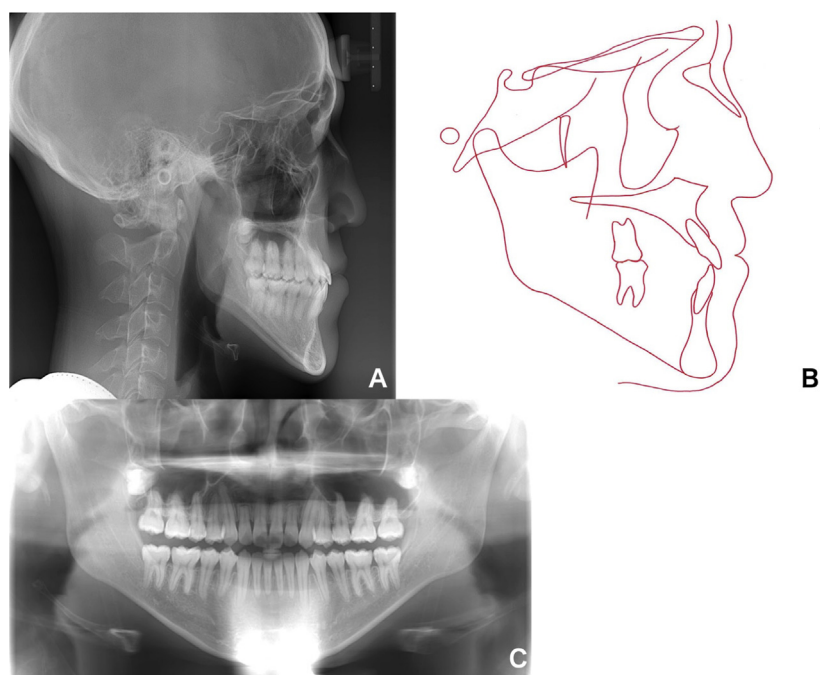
Patient 3: A-C, posttreatment cephalometric radiograph, cephalometric tracing, and panoramic radiograph.
